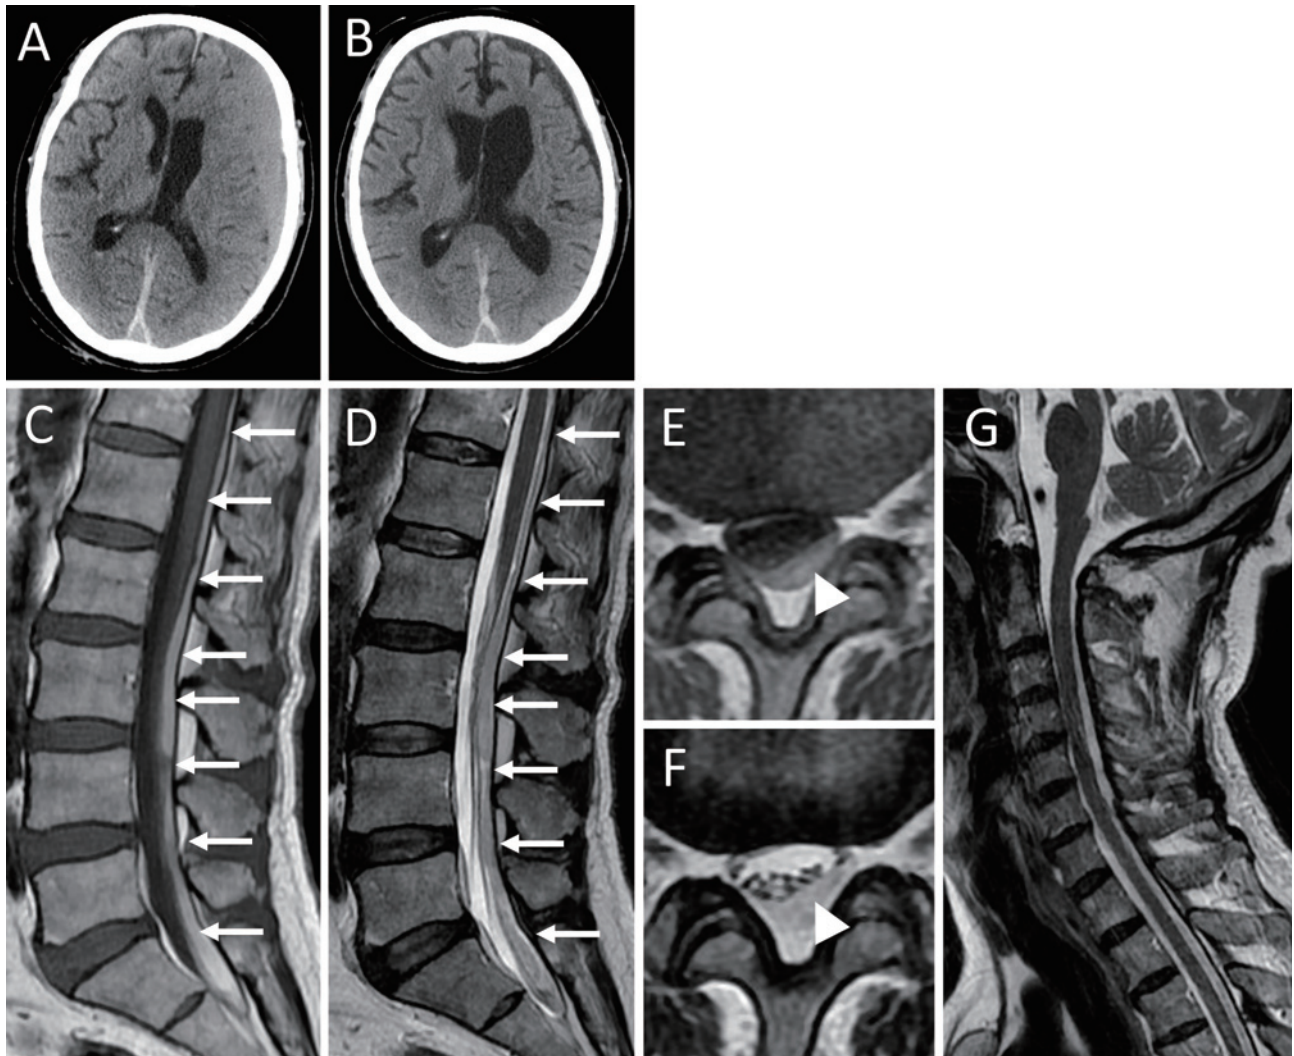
CT images of iCSDH and preoperative MRI of the spine. (A) Preoperative CT image shows left iCSDH with moderate midline shift. (B) Postoperative CT image shows that iCSDH is well evacuated. Both T1 (C and E) and T2 (D and F) hyperintense subdural hematomas (arrowheads in E and F) extend from the T11 to S2 levels (arrows in C and D), compressing the cauda equina. (G) Cervical MRI displays no sign of hematoma.
